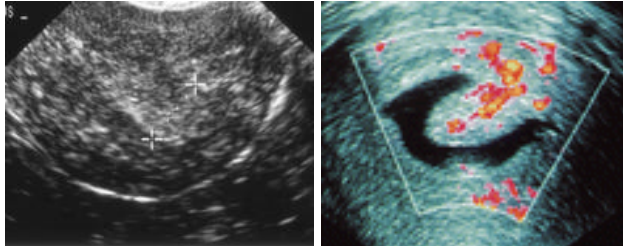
TVS Fig 2b: Doppler USG
